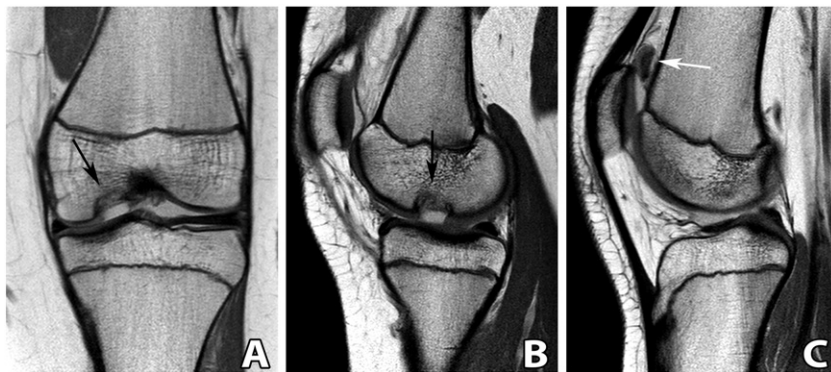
Patient 1: MRI, T1 PD TSE-weighted signal of the left knee. (A) Coronal view: an OCD lesion involving the cartilage and subchondral bone of the medial femoral condyle, approximately one centimetre in diameter, is visible (black arrow). (B) Sagittal view: an OCD lesion involving the cartilage and subchondral bone of the medial femoral condyle is visible (black arrow). (C) Sagittal view: a loose body is visible dorsal/cranial to the patella (white arrow).
